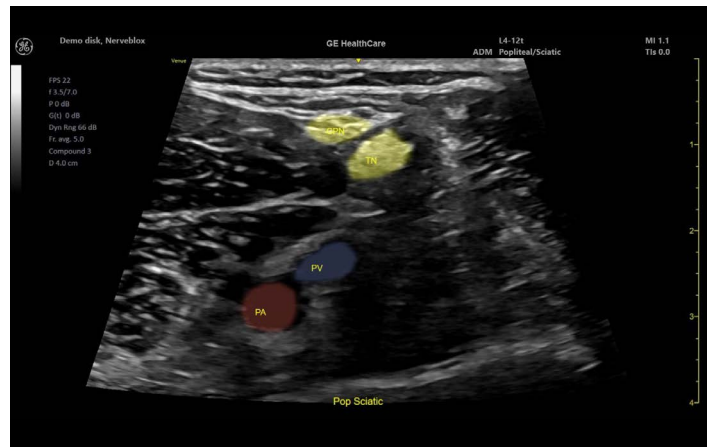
Ultrasound image of popliteal sciatic nerve.
